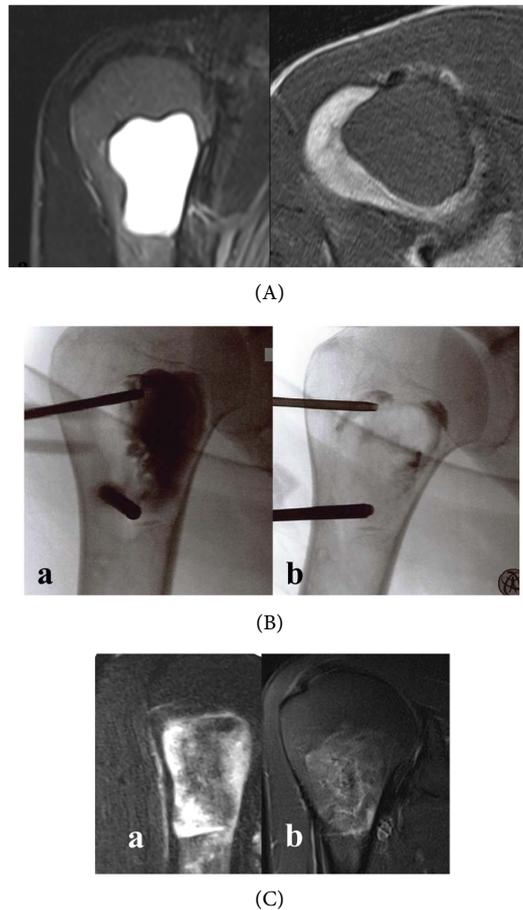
(A) Unicameral bone cyst following repeated fractures and interventions since age 6 years (December 2016); (B) Image intensifier documentation of the cyst filled with Iopamiro (a) and extrusion of the contrast medium by filling with Grafton® DBF Putty/BM (b) (January 2017); (C) MRI at 14 months ((a), March 2018) and 21 months ((b), October 2018) after injection of Grafton® DBF Putty/BM.
